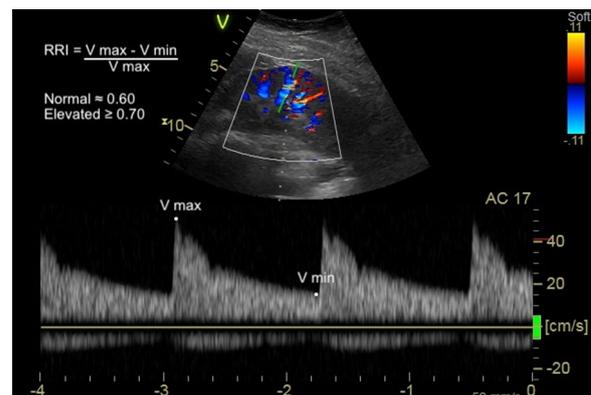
(abstract 000324) Example of how RRI is calculated from Doppler readings of intraparenchymal renal blood flow velocities
